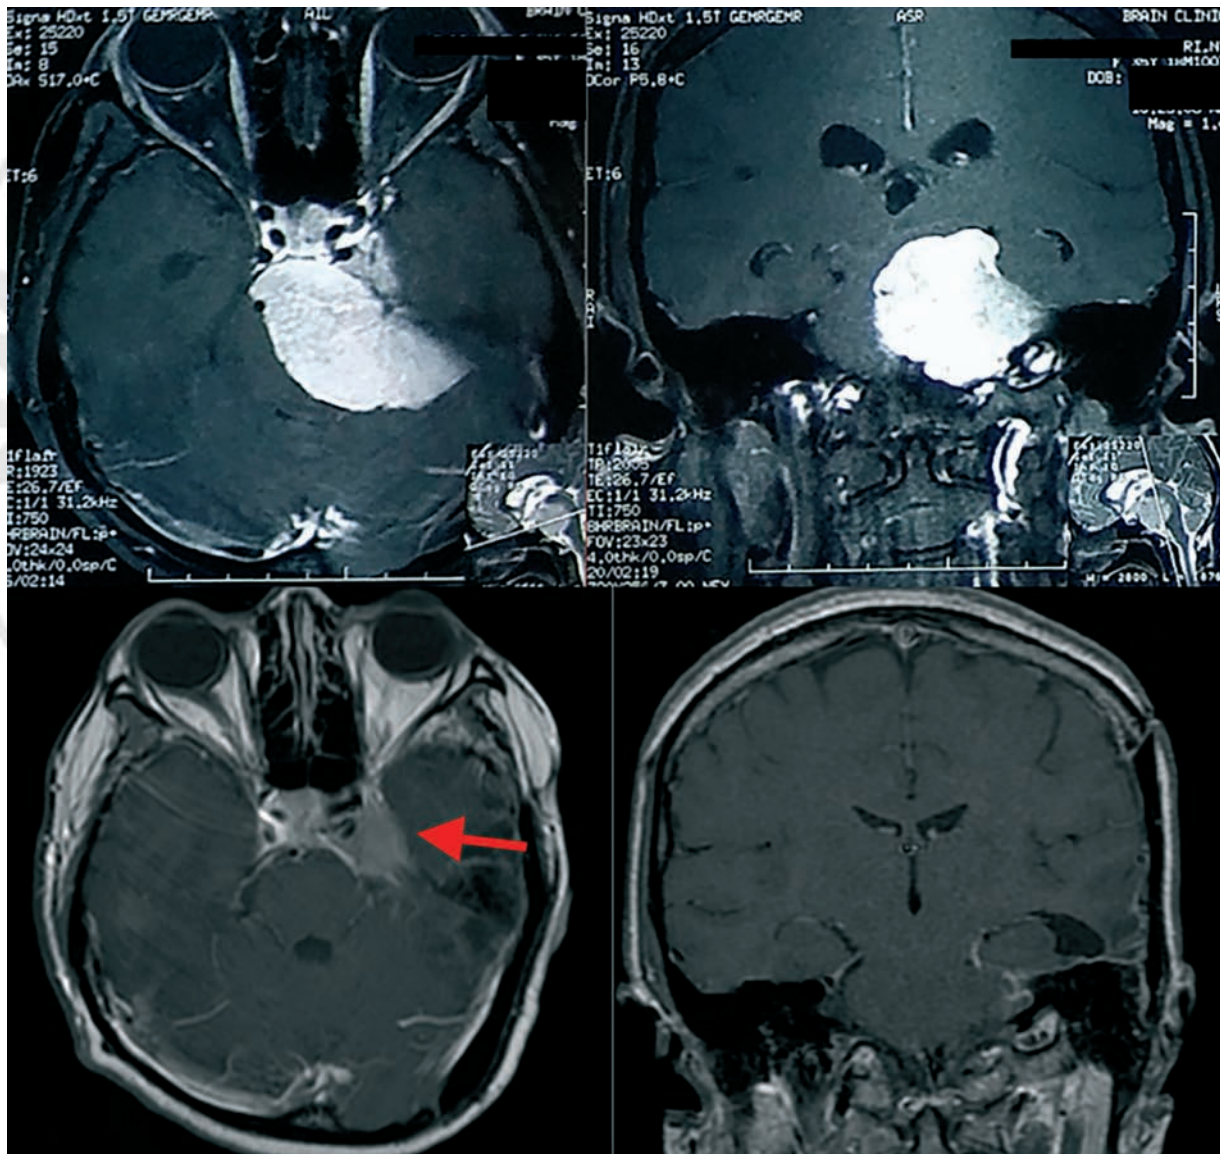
^{Q8} Pre- and postoperative magnetic resonance imaging (MRI) showing tumor extension into the cavernous sinus. Removal of the cavernous part of the tumor is limited if using the modified transpetrosal–transtentorial approach. (red arrow)
